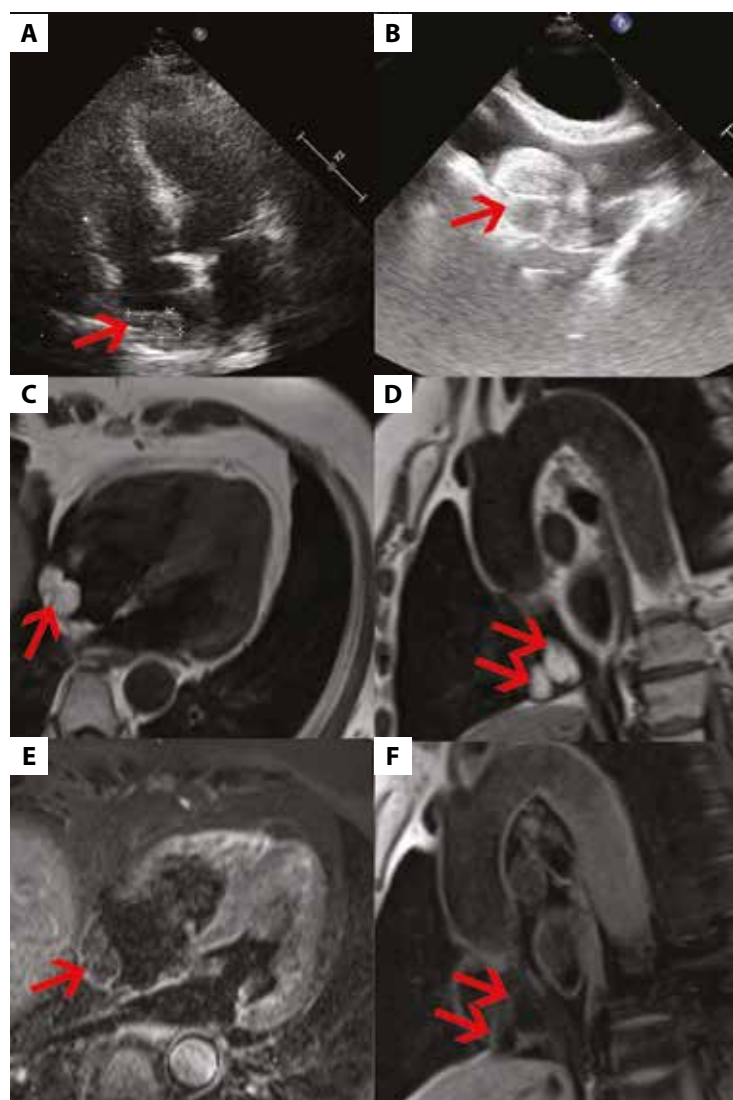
Cardiac lipoma (arrows), visualized using A. Transthoracic echocardiography. B. Transesophageal echocardiography — bicaval view. C. and D. Four chamber and short axis T1-weighted fast spin-echo. E. Cardiac magnetic resonance including four-chamber short-tau inversion recovery imaging. F. Four chamber view T1-weighted with a fat suppression sequence
